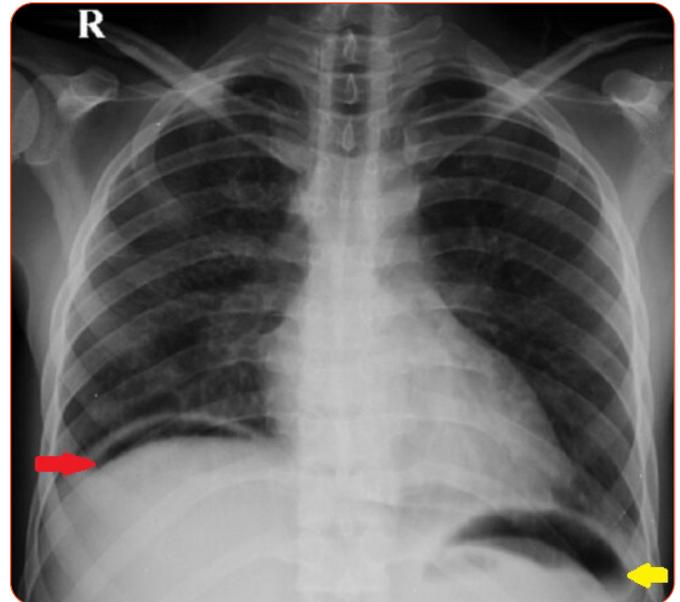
Erect chest x-ray showing free air, under the right diaphragm (red arrow) and under the left diaphragm (yellow arrow), due to perforation of hollow viscus. The free air is part of the pneumoperitoneum (courtesy Dr P Mercouris, Durban).
